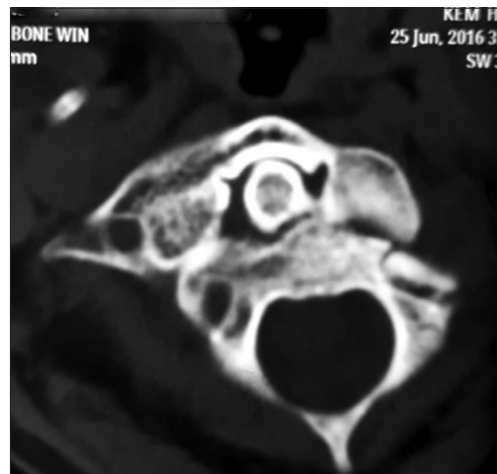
Computed tomography – Axial view showing left C2 superior articular process fracture with C1-C2 segment rotation
